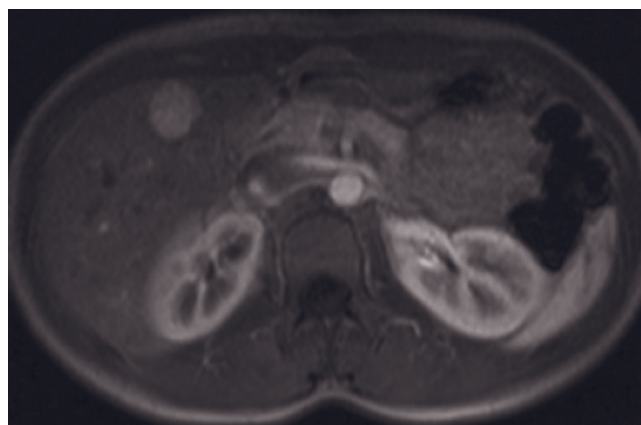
FNH, Gd-BOPTA-enhanced. SS-ETSE (a), SGE (b), and immediate (c), 90-s (d), and 1-h (e) postinjection Gd-BOPTA contrast images. There is a lesion in the right hepatic lobe that exhibits slightly high signal intensity on T2-weighted image (a), isointensity on T1-weighted image (b), and intense enhancement on immediate post contrast image (c) and fades as the background parenchyma on 90-s postcontrast image (d). This lesion has a central scar that is well seen on the T2-weighted image (arrow, a) and on the immediate postcontrast image (c). On 90-s postcontrast image (d) the scar enhances and acquires signal intensity comparable to the lesion. The lesion shows higher signal intensity than the background parenchyma 1 h after administration of contrast (e), and the scar demonstrates lower signal intensity than the lesion, consistent with lesional contrast uptake in this phase. (Courtesy of Guenther Schneider, M.D., Ph.D., Dept. of Diagnostic and Interventional Radiology, University Hospital Homburg/Saar, Germany.)
